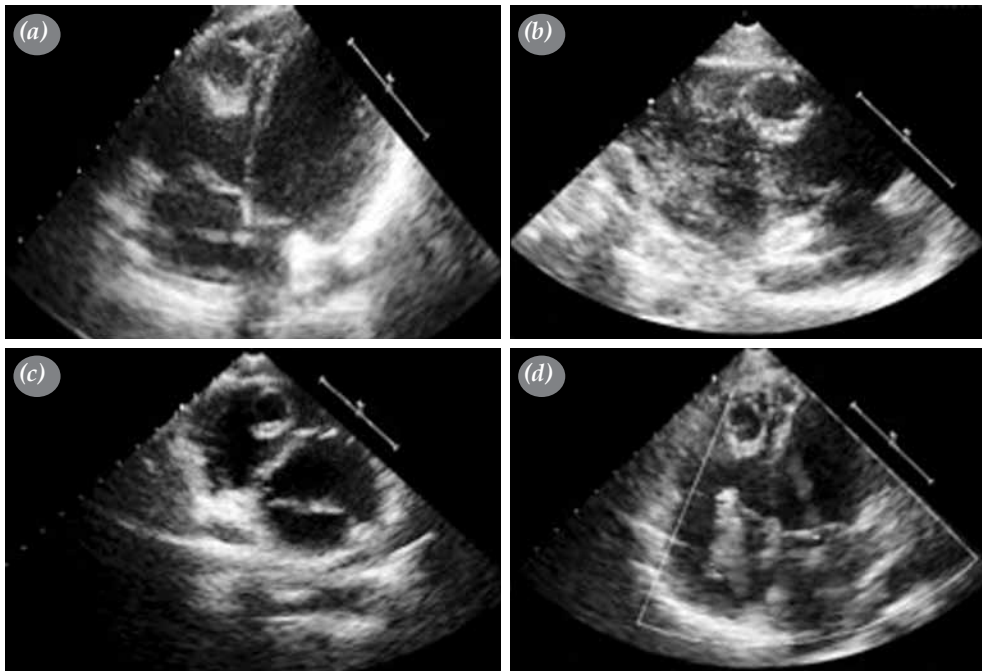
A transthoracic echocardiographic apical four-chamber (a-d) and short-axis view (b-c) showing a single echogenic, immobile, rounded mass with central cystic changes localized in right ventricle apex region and mild tricuspid regurgitation.
